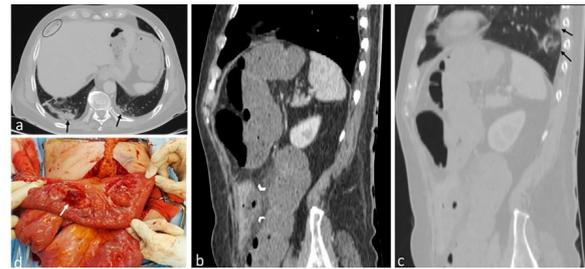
Perforated jejunal diverticulitis in a 72-year-old man with COVID-19 infection. Axial and sagittal CT images (a, c) show bilateral subpleural airspace opacities (black arrows) at the lower thoracic level. Subdiaphragmatic gas bubbles are noted (black oval) consistent with pneumoperitoneum. Sagittal CT image (b) reveals a small outpouching of the jejunum (white arrowheads) associated with mural edema and notable adjacent fat inflammation in keeping with perforated acute jejunal diverticulitis. Intraoperative photograph (d) demonstrates a perforated jejunal diverticulum (white arrow).
